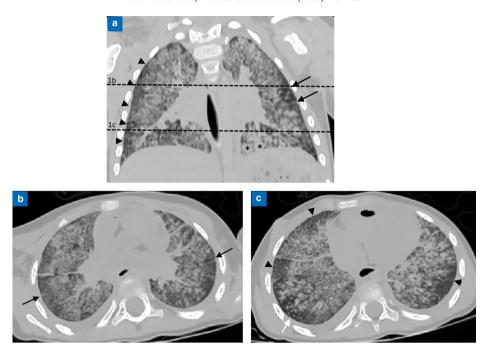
Postmortem computed tomography (CT). Thin-section coronal (a) and axial (b, c) reconstructed (5 mm section thickness) chest CT images show multiple ill-defined micronodules (white arrows) or ground-glass opacities excluding the region under the pleura (arrowheads) and some macronodules at the bases (asterisk) with interlobular septal thickening (black arrows).
